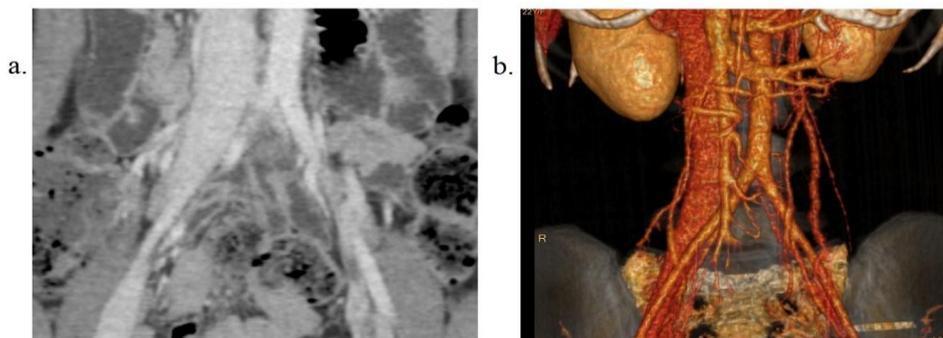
Coronal contrast CT and volume rendered image showing compressed left common iliac vein due to overlying right common iliac artery.
